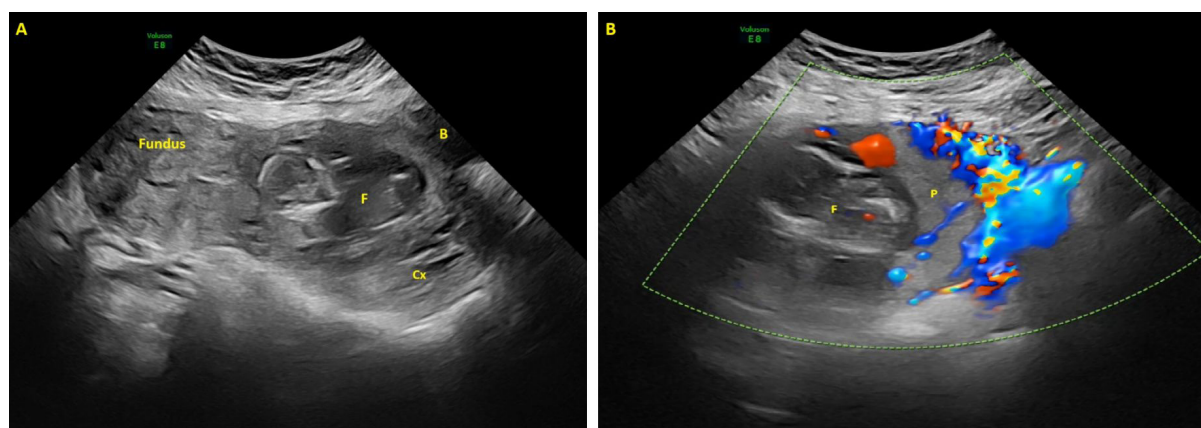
A) 12 weeks and 2 days cesarean scar pregnancy on grayscale imaging (F=Fetus, B=Bladder, Cx=Cervix) B) Color Doppler image showing increased vascularity surrounding the placental region (F=Fetus, P=Placenta)
